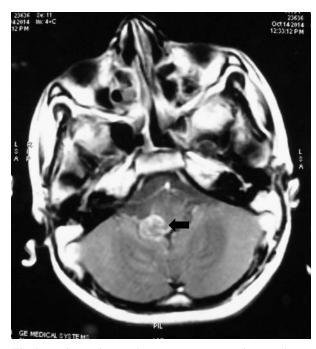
MRI brain showing heterogeneous ring-enhancing lesion in the brainstem.
